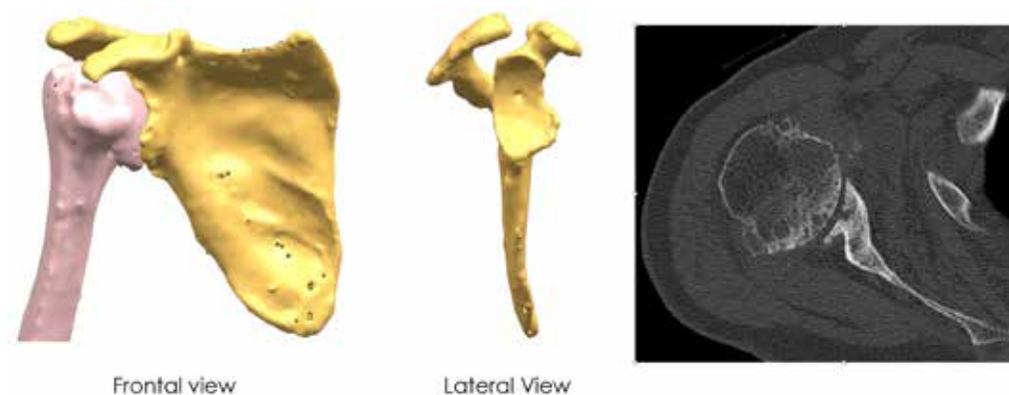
Preoperative situation, reconstruction based on the CT data
